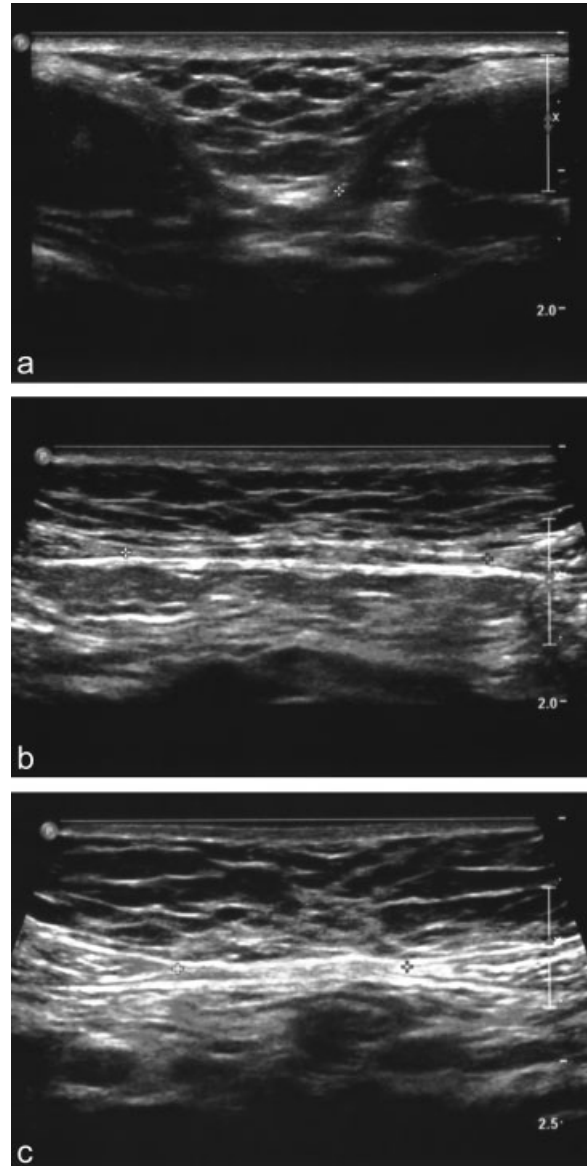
Representative ultrasonographic images of the linea alba and the rectus muscles in a woman with a small linea alba, 26 years of age, body mass index  $18.4 \text{ kg m}^{-2}$ . (a) Transverse scan at the origin at the xiphoid (10 mm), (b) 3 cm above the umbilicus (5 mm), and (c) 2 cm below the umbilicus (3 mm). There is an excellent visualization of the hypoechogenic rectus muscles in contrast to the hyperechogenic linea alba. The asterisks show the width of the linea alba. There is no difficulty in identifying the medial margins of the rectus muscles. The anterior and posterior sheaths of the rectus fascia are thick and clearly visible. There are no difficulties in identifying the rectus muscles infraumbilically.
